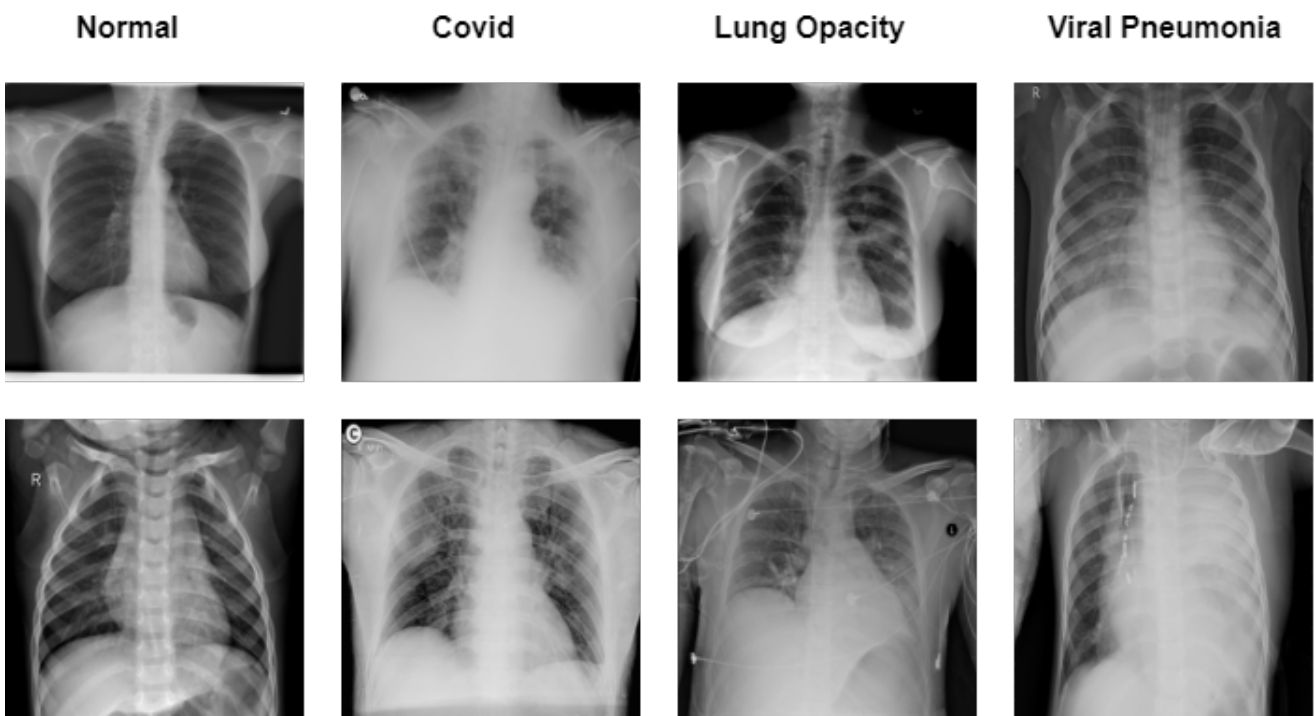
Sample image data (X-ray) for multi class classification to detect normal, covid, lung opacity and viral pneumonia.
